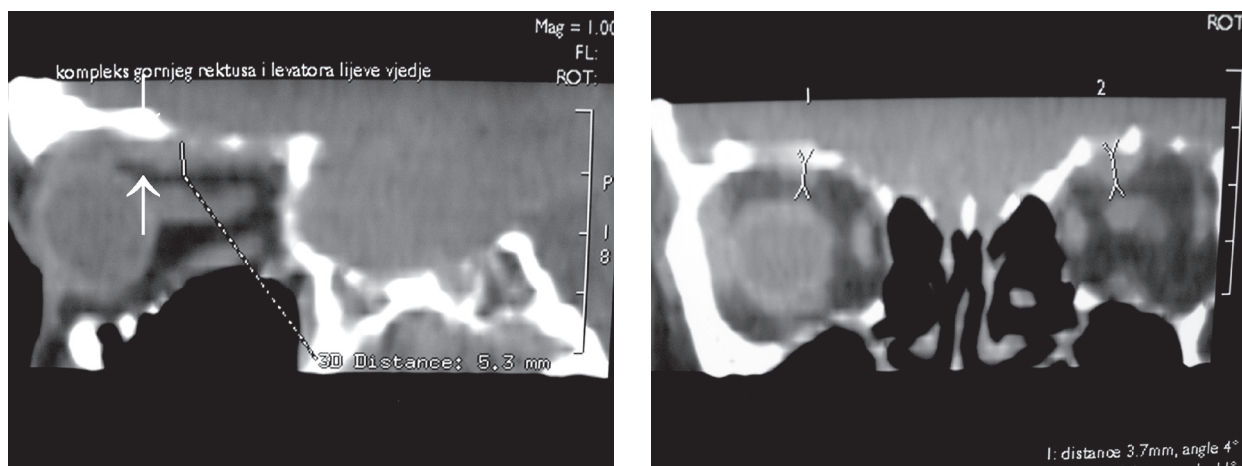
CT scan showing enlargement (arrow) of the upper rectus muscle and levator palpebrae superioris muscle complex.
